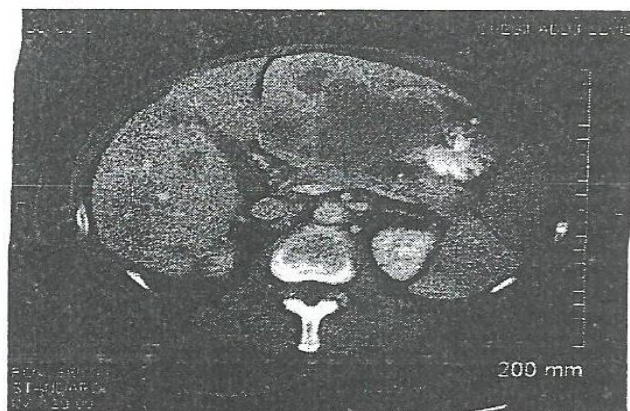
Axial CT image shows Thrombocytopenia [Mayr kur 2009]
